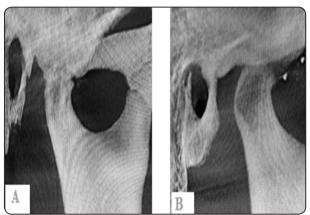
CBCT immediate PO showing; A reduced eminence height B hypertranslation of the condyle during mouth opening
